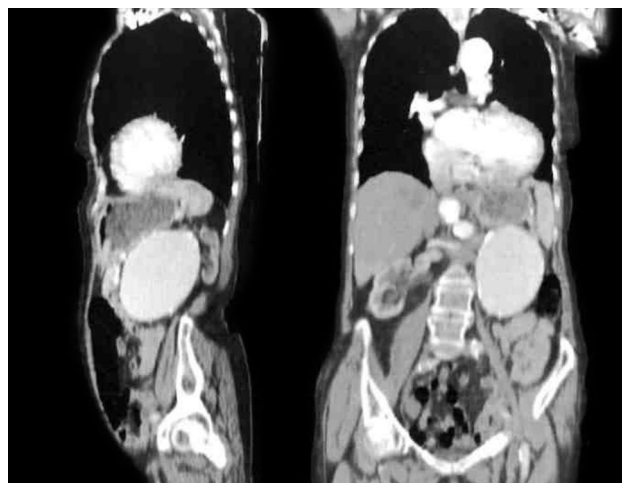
Computed tomography angiography of sagittal and coronal reformat images.
